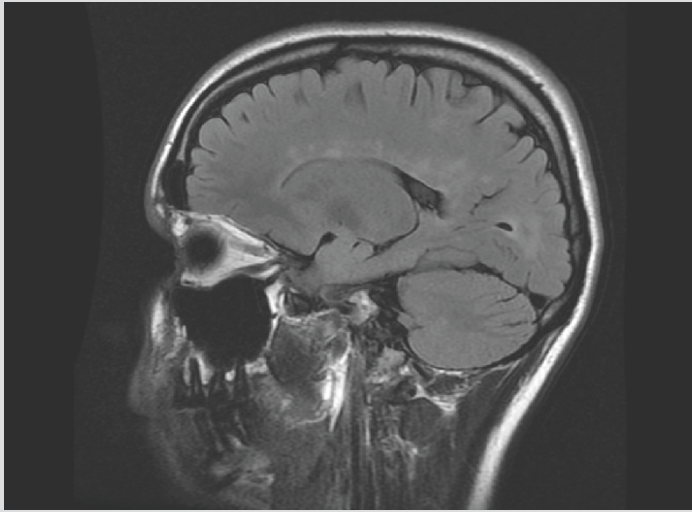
A sagittal FLAIR image of the brain showing multiple hyperintense white matter lesions, including 'Dawson's fingers.'
